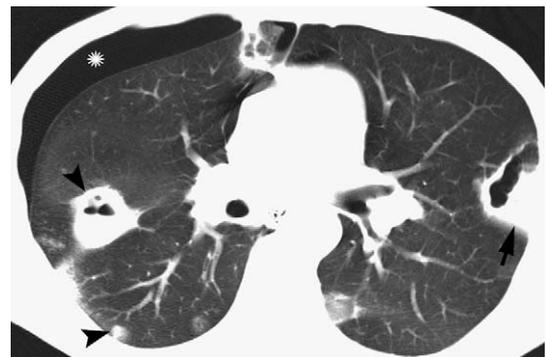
A 41-year-old man with septic embolism due to intravenous drug use. CT image (5-mm collimation) shows multiple peripheral nodules (arrowheads) of varying sizes, some of which are cavitary. A cavitating subpleural wedge-shaped opacity is noted within the left upper lobe (straight arrow). Small right pneumothorax (asterix) is presumably related to rupture of a cavitary lesion (not shown) into the pleural space.
